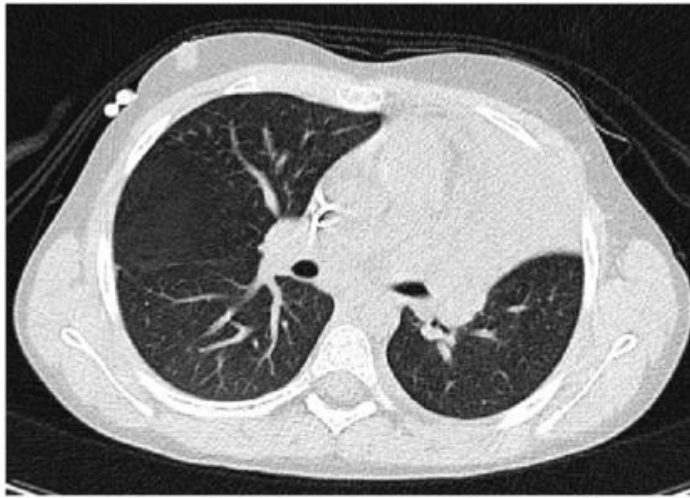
A) CT showing mass lesion
